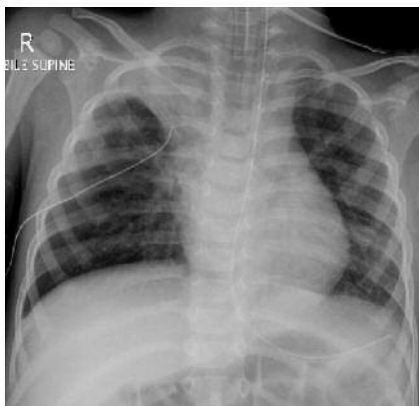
Case 1: post-intubation chest x-ray demonstrating right upper and left lower lobe changes in a 2-year-old boy.
